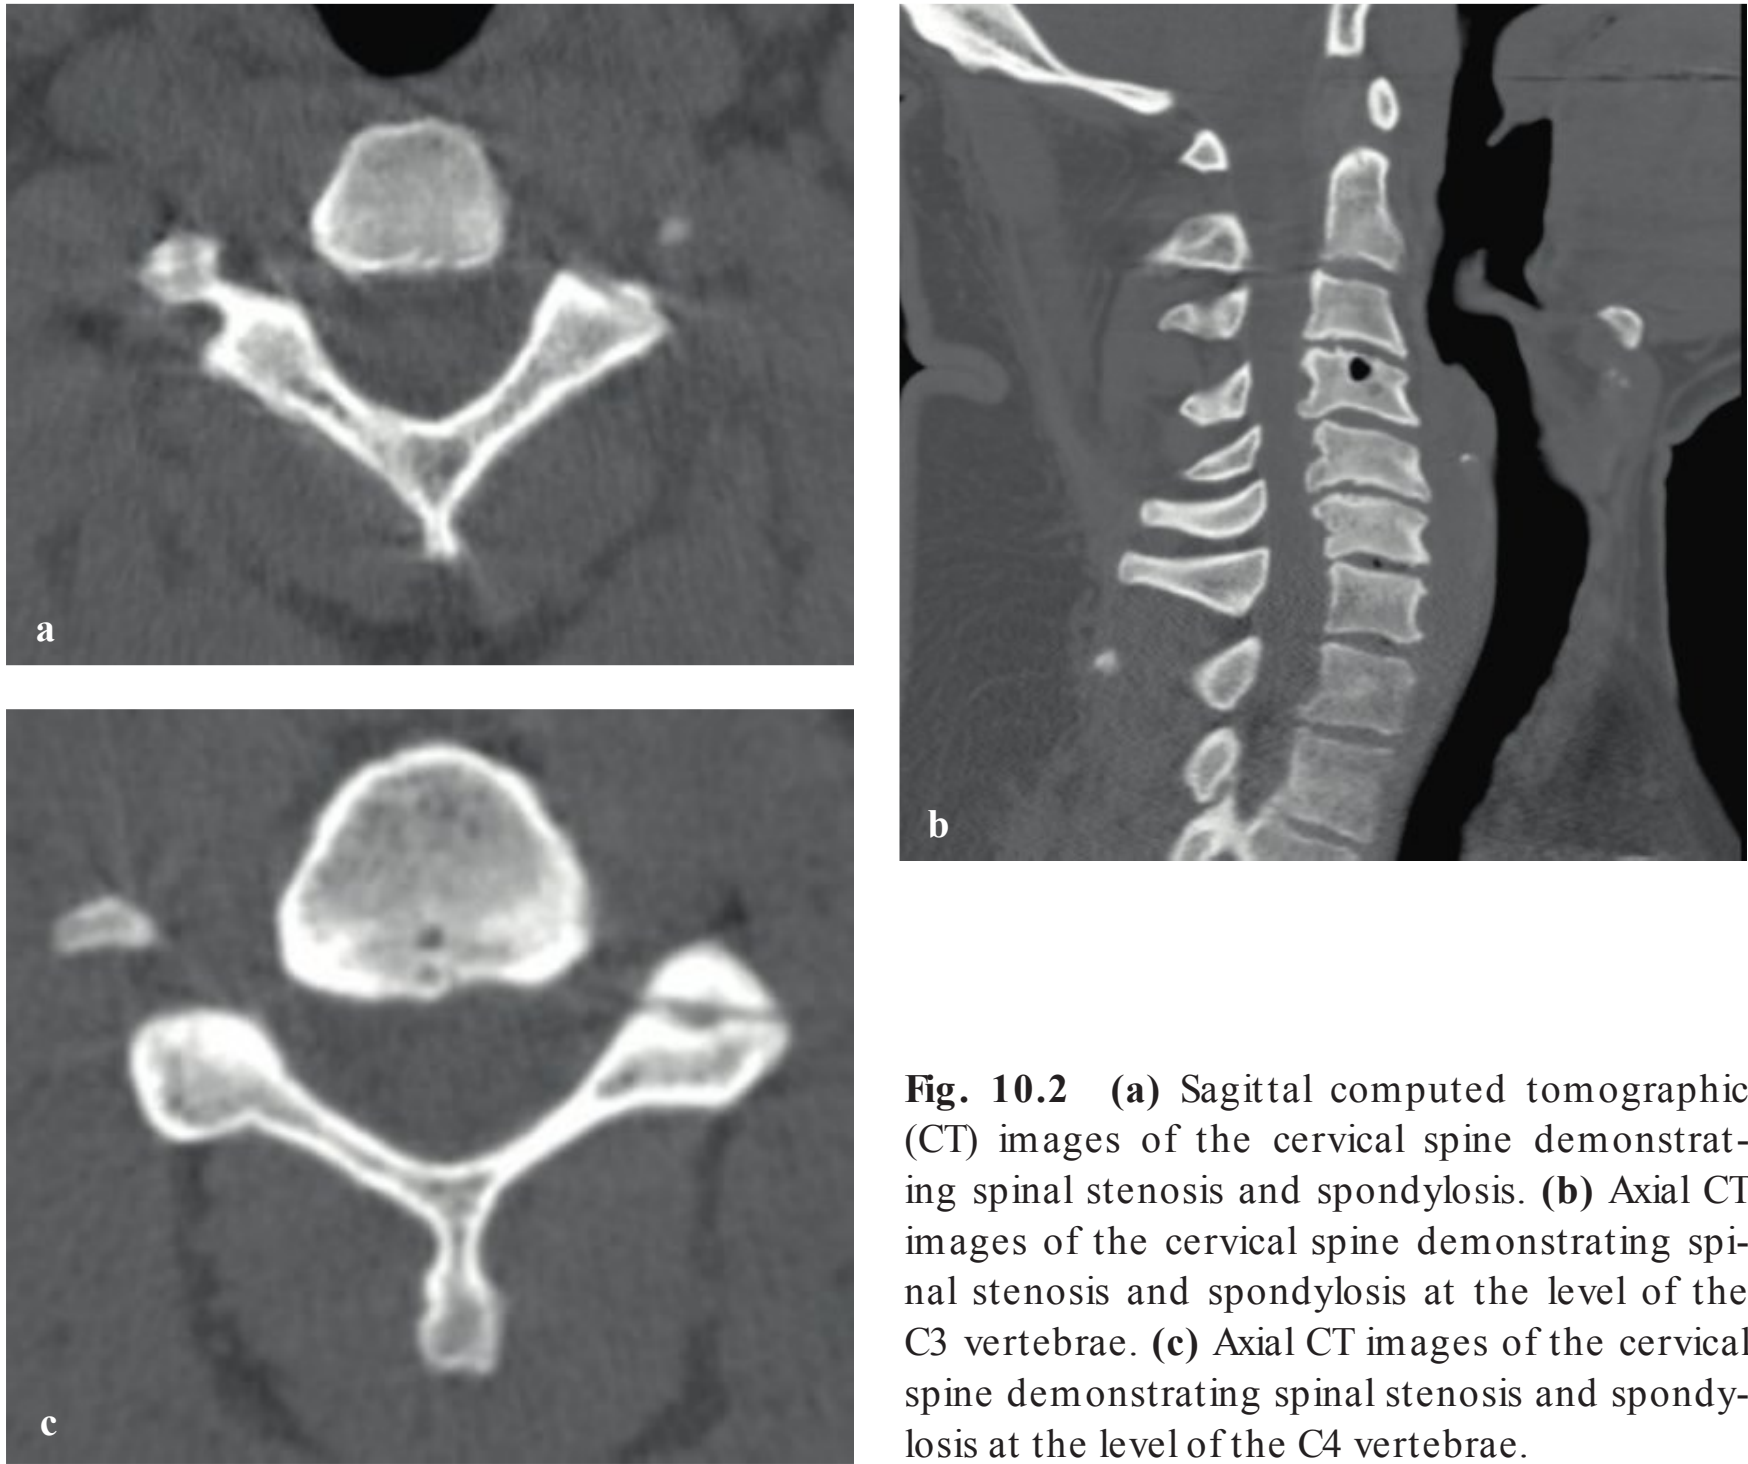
(a) Sagittal computed tomographic (CT) images of the cervical spine demonstrating spinal stenosis and spondylosis. (b) Axial CT images of the cervical spine demonstrating spinal stenosis and spondylosis at the level of the C3 vertebrae. (c) Axial CT images of the cervical spine demonstrating spinal stenosis and spondylosis at the level of the C4 vertebrae.
